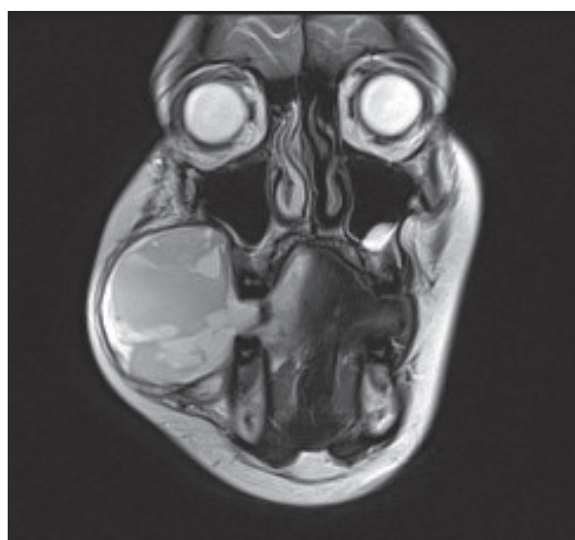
Magnetic resonance imaging head scan. This coronal view shows a complex soft tissue mass originating from the right buccal mucosa and expanding into the oral cavity.
